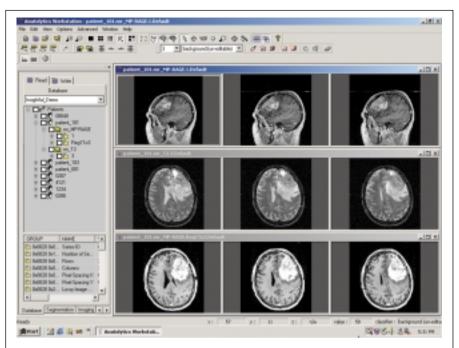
Screen shot demonstrating multi-modality registration results. Images in the top row show three consecutive sagittal slices of an aggressive brain tumor acquired with a T1-weighted 3D magnetic resonance image (MRI). The images in the middle row show a T2-weighted axial MRI acquisition of the same patient. It is difficult to correlate features between these two sequences The bottom row shows the results of registering the sagittal T1 images with the axial T2 images. The images derived after registration permit a direct comparison between the two sequences.
